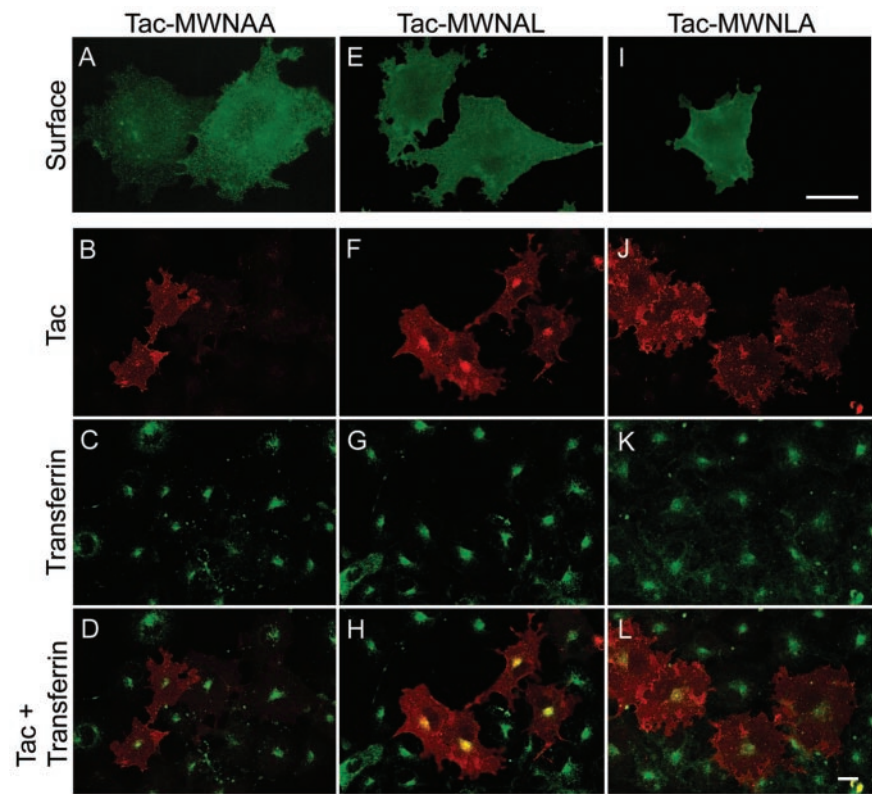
Internalization of Tac-PSMA chimeras harboring mutations in the di-leucine signal. Surface expression as well as internalization of PSMA was performed as described in figure legend 5. (A, E, and I) Surface expression of Tac in COS-7 cells expressing Tac-MWNAA, Tac-MWNAL, and Tac-MWNLA chimeras, respectively. (B, F, and J) Internalization of Tac chimera mutants. (C, G, and K) Uptake of FITC-transferrin. (D, H, and L) Merged images. Representative medial optical sections are shown. Yellow color in H indicates the codistribution of FITC-transferrin and internalized PSMA. Bars, 10 μm (A, E, and I) and 5 μm (B, C, D, F, G, H, J, K, and L).
